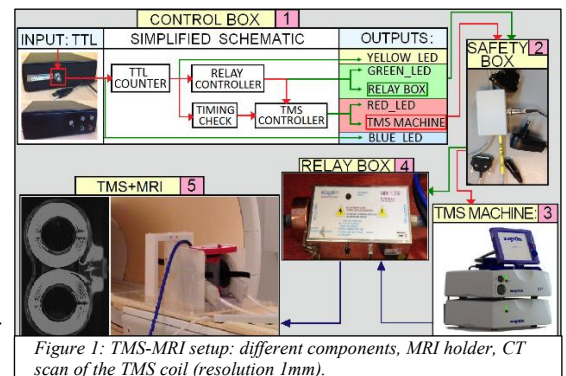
TMS-MRI setup: different components, MRI holder, CT scan of the TMS coil (resolution 1mm).
